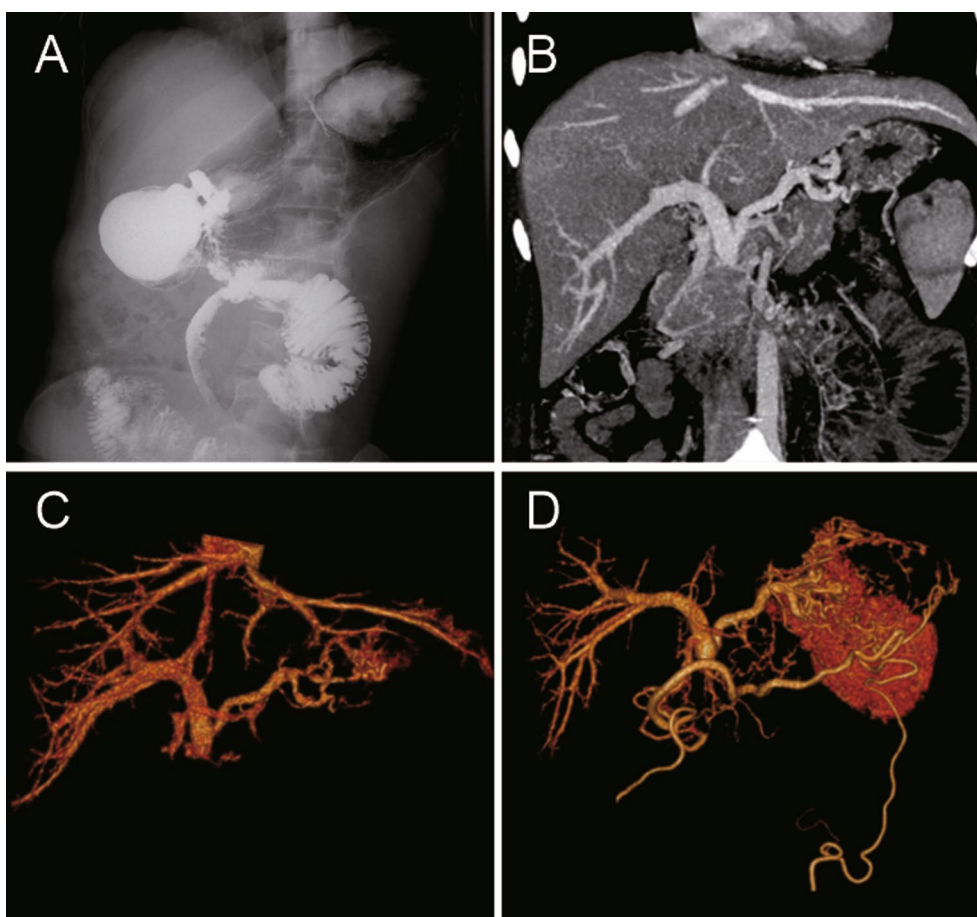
A The X-ray imaging showed that the mucosal folds of the proximal jejunum disappeared, the bowel looked like a lead pipe, and the barium was impeded when passing through. B and C The computed tomography angiography showed the left branch of portal vein, superior mesenteric vein, and splenic vein were totally clotted, and multiple collateral vessels were observed in the gastric submucosa and epigastric area. D The second three-dimensional reconstruction of portal venous system thrombosis showed that all the veins were still clotted, and the collateral vessels were more obvious than those in the first reconstruction
